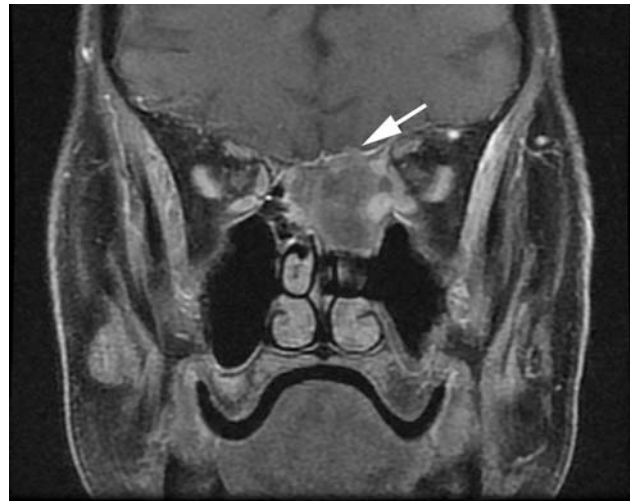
An MRI shows a mass expanding and filling the upper portion of the nasal cavity, extending through the cribriform plate (*arrow*), showing early intracranial extension
